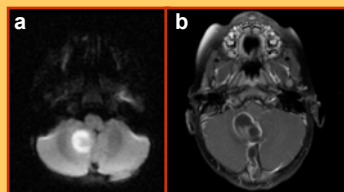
a) DWI shows markedly restricted diffusion, b) T1W MR after Gadolinium shows rim enhancement that extends along the sinus tract toward the skin surface.
